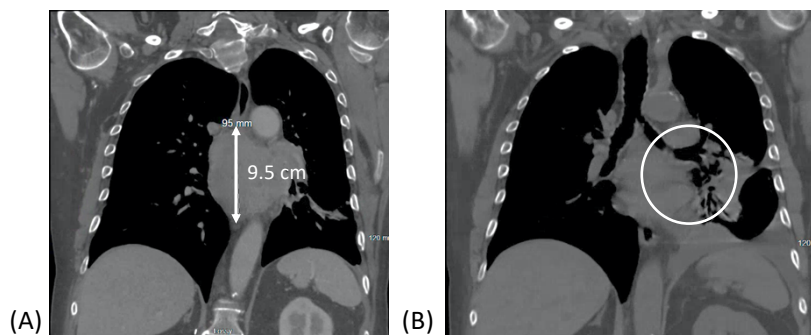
Treatment outcomes for a patient with locally advanced extrabronchial MCAO induced by metastatic renal cell carcinoma treated with 8 Gy x1 followed by our image-guided I-PDT 48 h after the p-XRT. (A) CT scan 13 days prior to treatment showing a 9.5 cm extrabronchial tumor blocking the airway. (B) CT scan 40 days after the I-PDT showing open left mainstem airway (marked with a circle) resulting in significant improvement in breathing.
